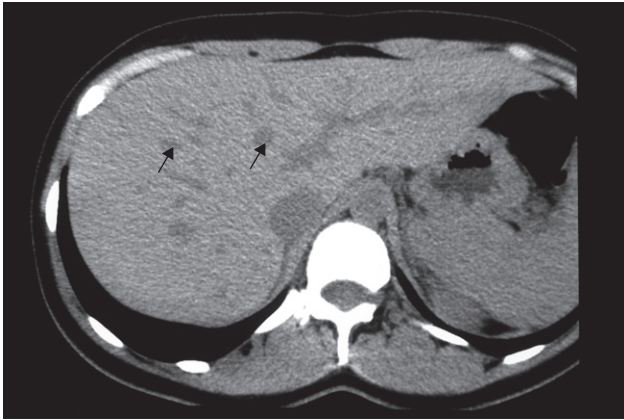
CT scan of normal liver showing unopacified veins (arrows), which should not be confused with metastases.
